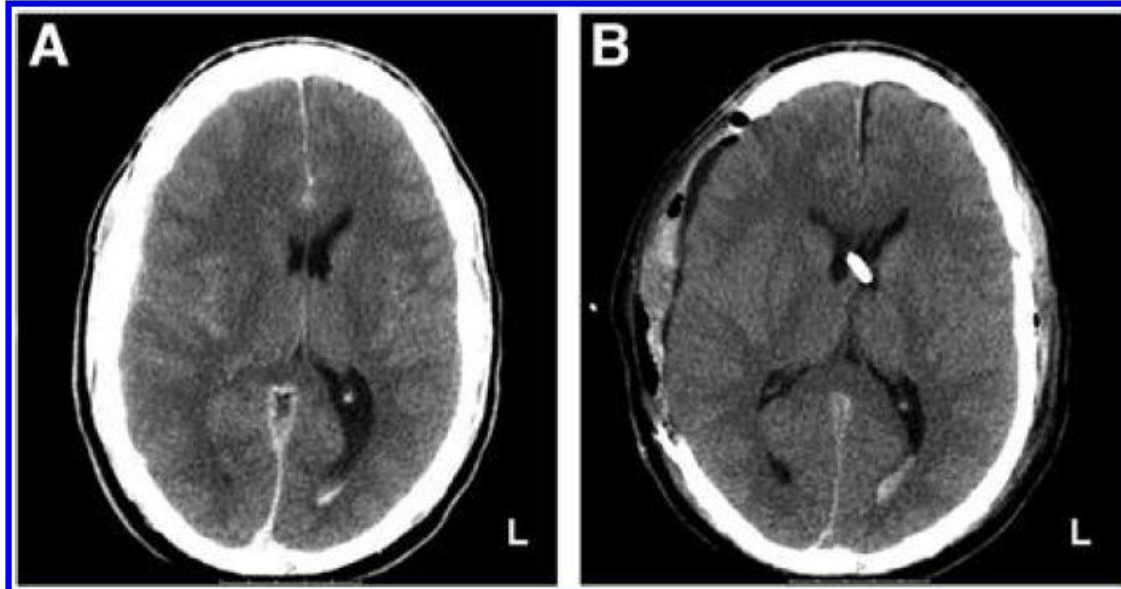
This skier sustained a severe head injury after a fall from approximately 5 m after a ski jump. He wore a helmet at the time of the accident. At admission, his Glasgow Coma Scale was 3 and the initial computed tomography scan revealed intraventricular hematoma, subarachnoid hemorrhage, and a thin acute subdural hematoma with diffuse swelling of the right hemisphere (A). An external ventricular drain was inserted in the emergency department, and a decompressive hemicraniectomy was performed (B). On follow-up, the patient had a Glasgow Outcome Scale of 5 (none or minor deficit).
